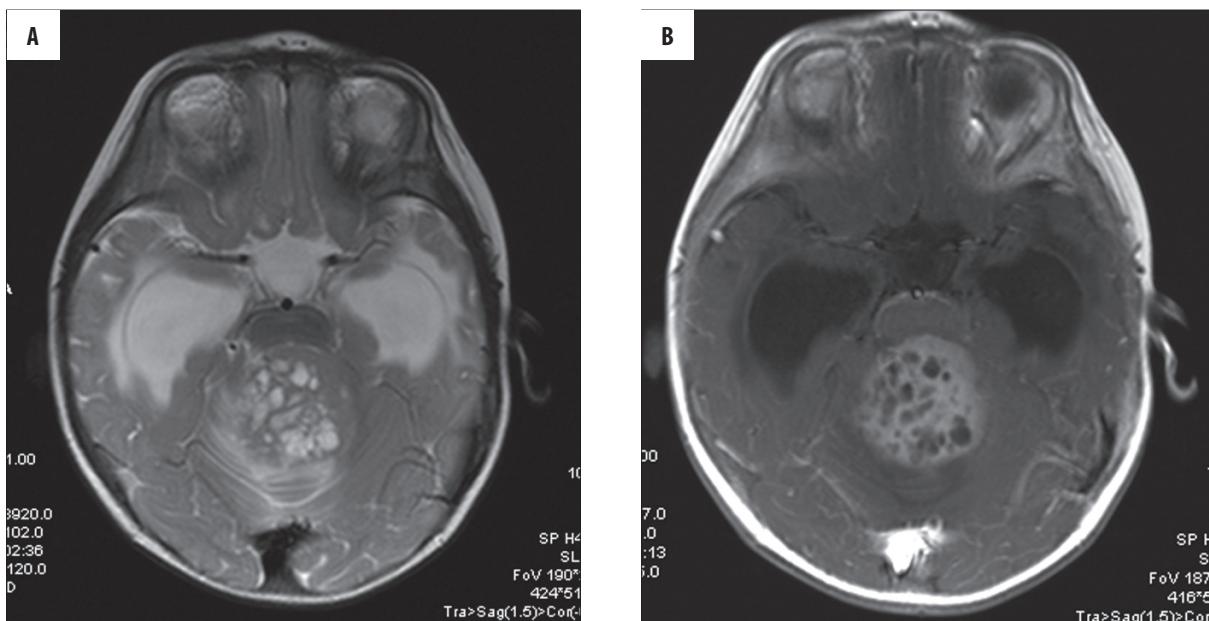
MRI of the retrospectively reviewed 9-month-old boy. (A) Axial T2WI. The lesion displays mixed signal intensity, with hypointensity similar to the cortex and hyperintensity representing tiny cysts. (B) Axial T1WI. Contrast enhancement of the tumour is inhomogenous due to its cystic parts.
